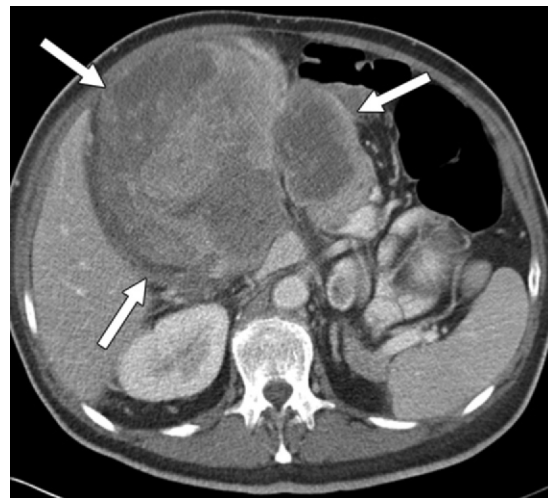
Pleomorphic liposarcoma in a 59-year-old man. Axial contrast-enhanced CT image shows a heterogeneous soft-tissue retroperitoneal mass (arrows) without detectable fat attenuation.
